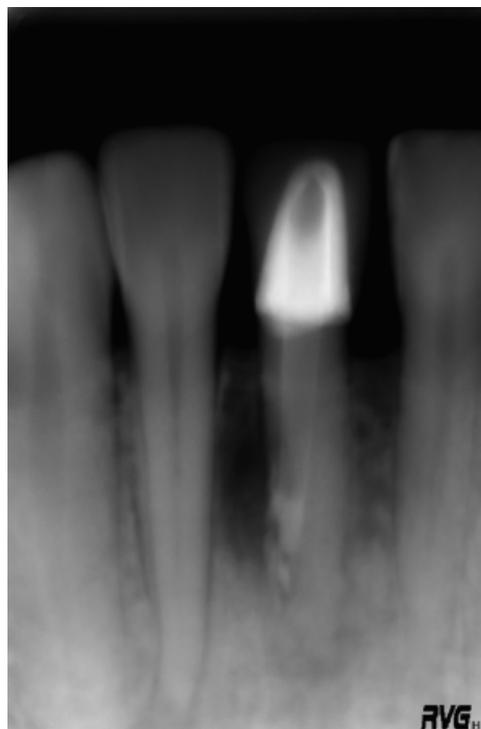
Radiograph showing different localization for perforation that occurred during access preparation or endodontic treatment. Radiograph showing massive bone destruction after perforation of a glass fiber post in a lower, anterior tooth.
